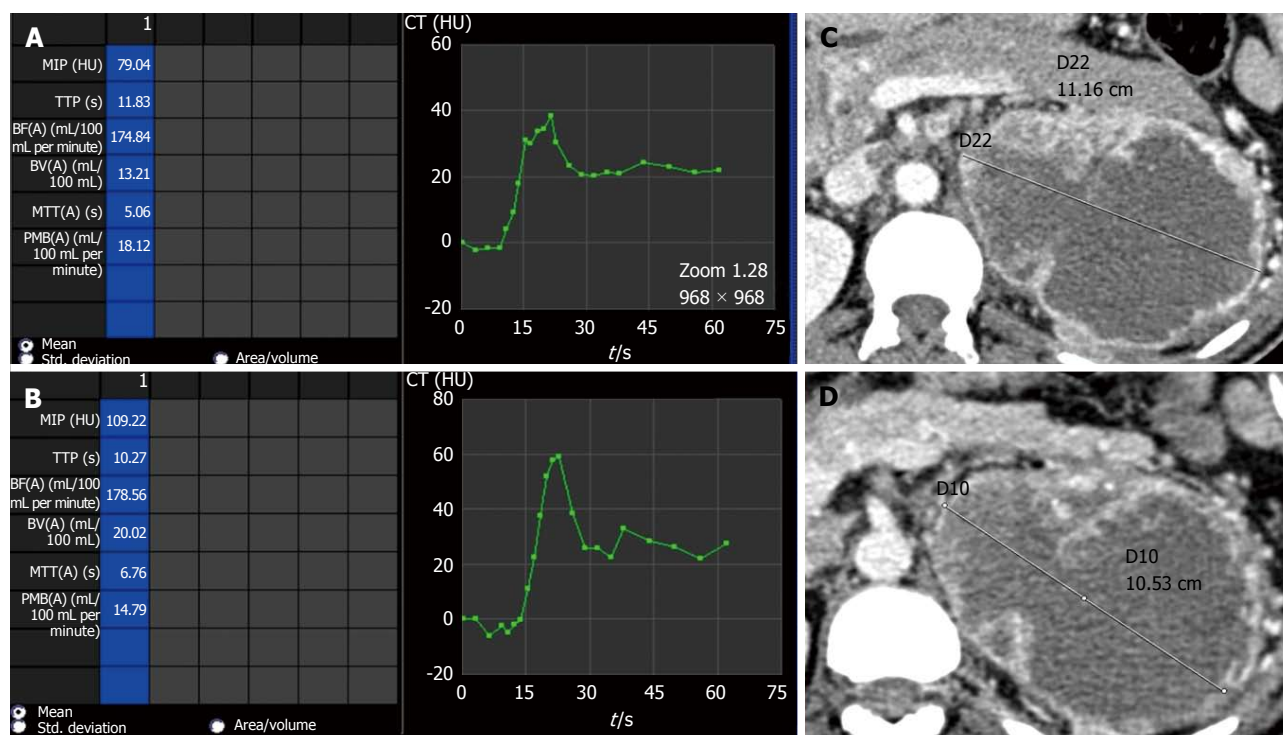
Perfusion parameters vs size evaluation in depicting partial response. Comparison of perfusion parameters in a case of left side clear cell renal cell carcinoma after start of anti-angiogenic therapy. Follow-up scan at 6 mo interval (B) showed at 6 mo interval shows decrease in permeability as compared to baseline scan (A) suggestive of partial response. However, no change in size of lesion noted between baseline (C) and follow-up (D) scans which would have been labelled as stable disease. MIP: Maximum peak intensity; TTP: Time to peak; BF: Blood flow; BV: Blood volume; MTT: Mean transit time; PMB: Permeability; CT: Computed tomography.
